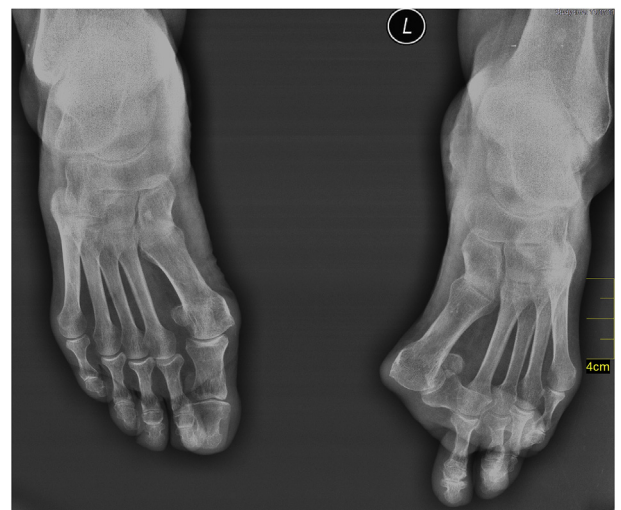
Anteroposterior standing radiograph showing a severe left hallux valgus deformity with dislocation of the left first metatarsophalangeal joint.
